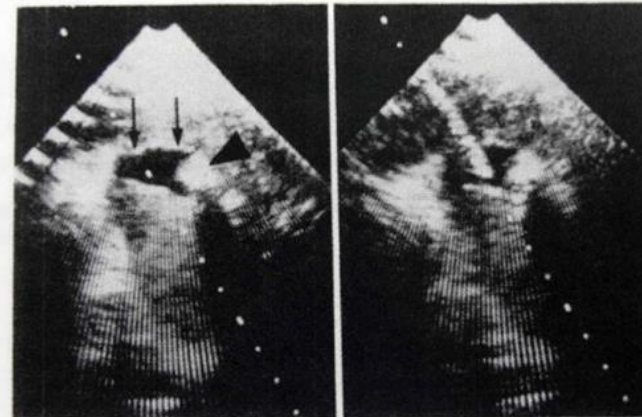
Same patient as in Figure 5. Transverse sonograms using the seventh intercostal space show hepatolithiasis. a. Sonogram demonstrates the dilated bile duct (arrows) and hepatolithiasis (arrowhead) with an acoustic shadow. b. The PTBD needle was inserted into the bile duct using the broken line as a guide. A 3.5-MHz transducer was used.
